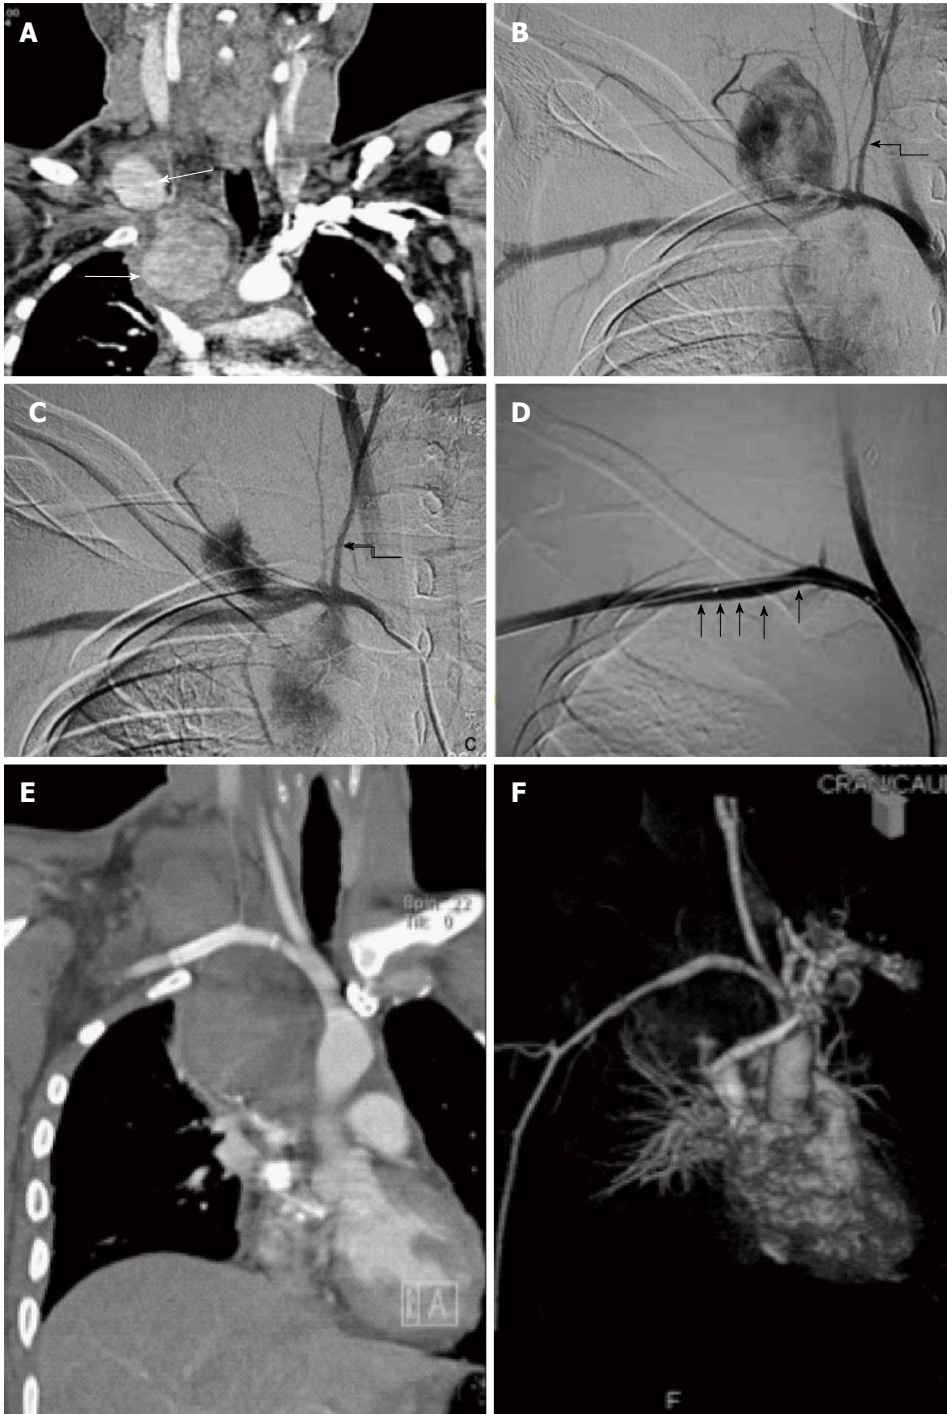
Peripheral vascular injury. A 56-year-old male with multiple rib fractures and neck swelling following road traffic accident. A: CT angiography showed two distinct pseudoaneurysms arising from the proximal right subclavian artery, one cervical and other intrathoracic (arrow). However, there was good opacification of distal subclavian artery with no disruption in continuity, ruling out transection (curved arrow); B, C: DSA corroborated CT findings and revealed two large pseudoaneurysms arising from the proximal right subclavian artery, lateral to the origin of thyrocervical branch (arrow); D: Subsequently, guidewire was manipulated across the PsA and covered stent graft (arrow) was deployed, excluding the origin of right common carotid artery. Post stenting angiography showed no opacification of pseudoaneurysm with good flow in distal subclavian artery; E, F: Follow up CT angiography done 2 wk later revealed both the pseudoaneurysm to be thrombosed. The stent (arrow) was optimally placed stent (arrow) with preservation of distal flow across it. PsA: Pseudoaneurysm; DSA: Digital subtraction angiography.
